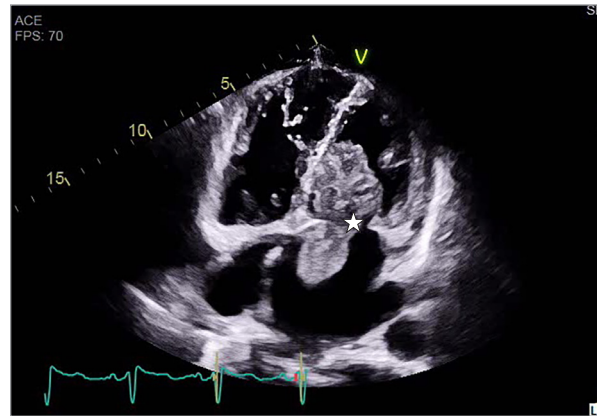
A 2-dimensional transthoracic echocardiogram provides a subxiphoid view of the patient's myxoma. The star indicates the myxoma's site of attachment to the interatrial septum. The myxoma measured 4.0 × 9.0 cm.
